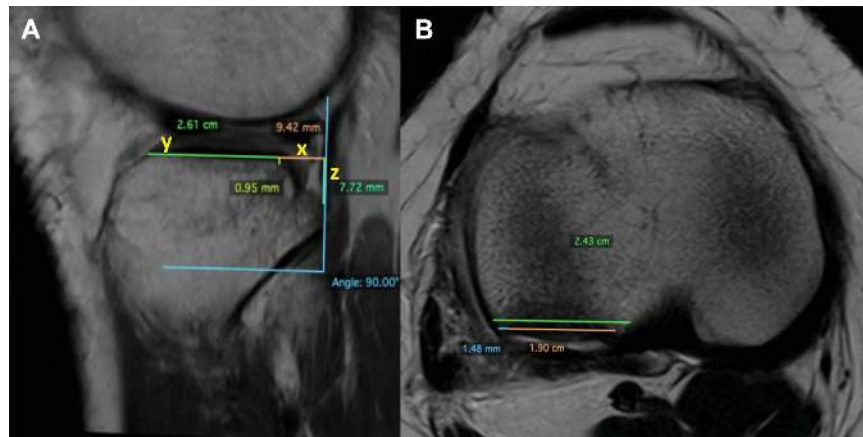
Measurement technique for tibial plateau impaction fracture. Sagittal image on magnetic resonance imaging scan demonstrating tibial plateau depth measurements in a control knee without an impaction fracture. Line y is drawn first along the subchondral bone from the anterior to posterior aspect of the articular surface. Next, line x, the posterior articular marginal distance, is drawn extending from the posterior extent of the articular surface to a line perpendicular to line y and placed as a tangent line along the posterior-most aspect of the proximal lateral tibia. Line z, the posterior height, is measured from the level of the articular surface to the level where bone is first contacted along the posterior tangent line. Posterior articular marginal percentage is calculated as  $x/(x + y)$ .
